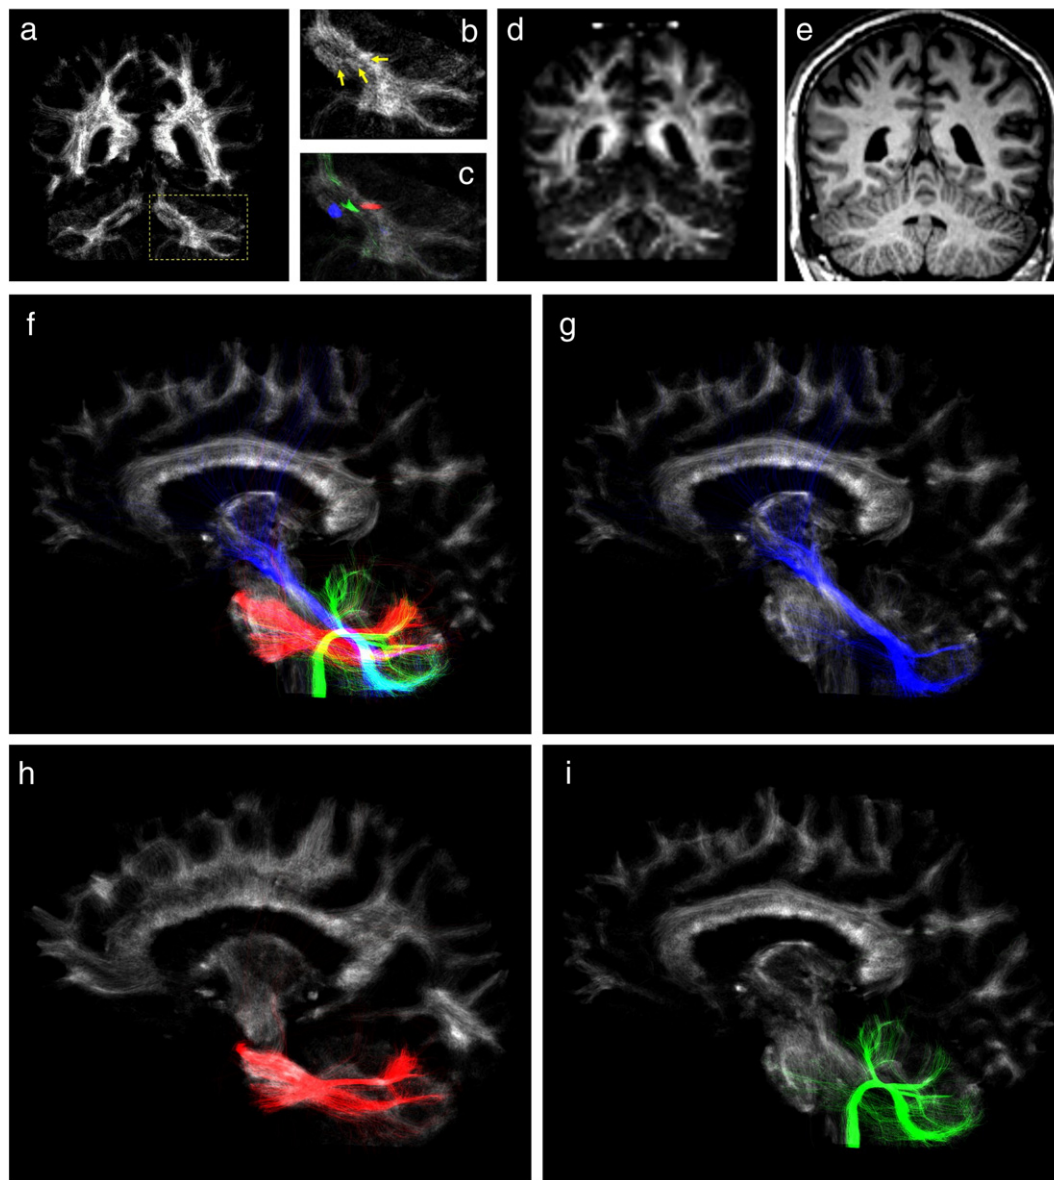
TDI example of the cerebellar peduncles. (a) Coronal whole-brain track-density map (1,500,000 tracks, 250 μm isotropic grid) from subject *S1*. (b) Zoomed-image of the region highlighted in (a): 3 distinct white matter regions can be seen (see arrows), which correspond to the superior (SCP), middle (MCP) and inferior cerebellar peduncles (ICP). Three separate seed regions were positioned in these 3 structures, and probabilistic tractography was then performed (1000 tracks/seed ROI). (c) Zoomed-region with the tracks overlaid (blue: SCP, red: MCP, green: ICP; only tracks within a 2-mm slab are shown). (d) Corresponding coronal FA map (interpolated to 1 mm isotropic resolution). (e) Corresponding coronal MPRAGE. Note the lower contrast and insufficient demarcation of the various cerebellar peduncles in the FA map and MPRAGE image. (f) Sagittal whole-brain track-density map with the results of the seeded fiber-tracking superimposed (blue: SCP, red: MCP, green: ICP). For clarity, the three different results are separately shown in figures (g), (h), and (i) for the SCP, MCP, and ICP, respectively. Note that the fiber-tracking results are generated from the original (low resolution) DWI data, and the TDI maps are only used to define the seed ROIs.
